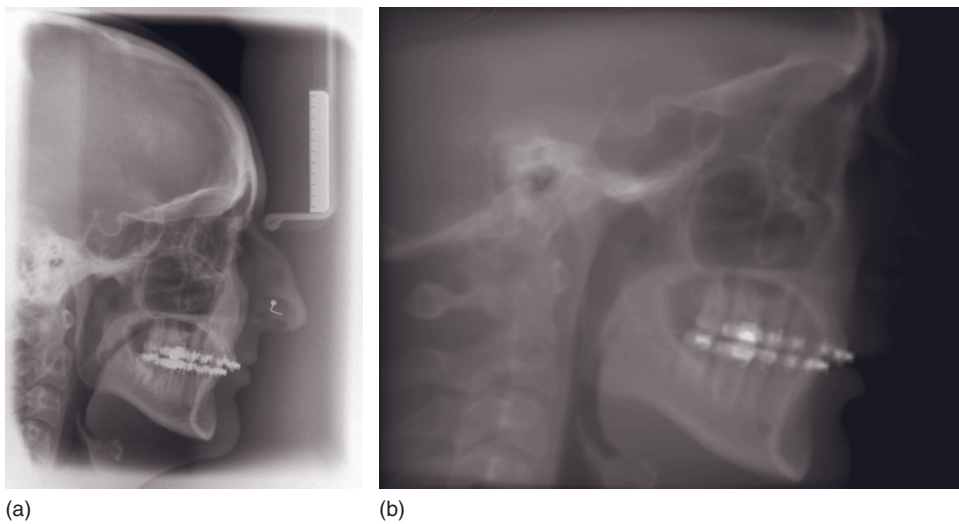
Examples of cephalometric radiographs produced by different methods. (a) Conventional cephalometric radiograph and (b) Reconstructed cephalometric radiograph produced by ray-sum methods with no distortion. (With permission from Imaging Sciences International.)
